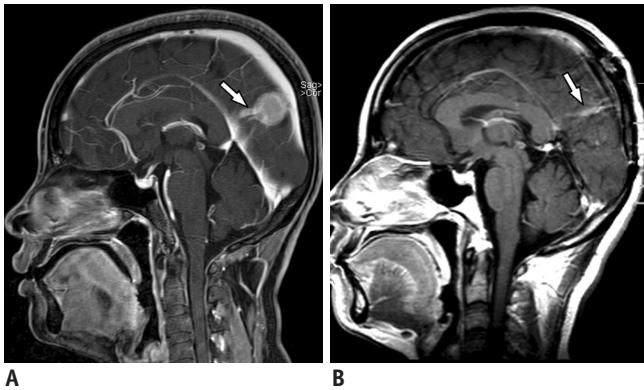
43-year-old male with multiple cerebral abnormalities. A. Sagittal contrast-enhanced MR image demonstrated absence of splenium of corpus callosum and vascular malformations in corpus callosum and lateral ventricles. Straight vessel was narrow (arrow), with two vessels originating from anterior part and connecting to SSS. B. Axial contrast-enhanced MR image showed that above vessels were in posterior part of falx cerebri (arrow). Vascular malformations were mainly located near right lateral ventricle. MR = magnetic resonance, SSS = superior sagittal sinus
